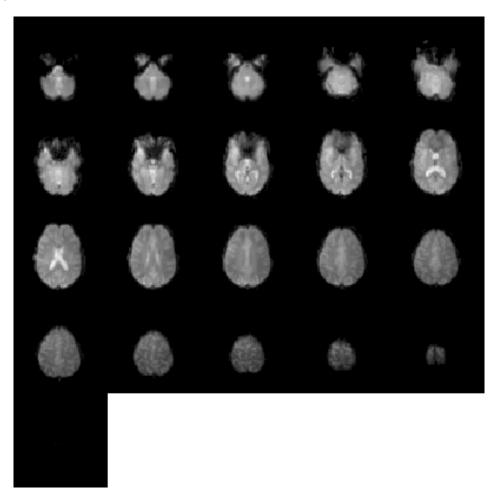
Axial slices of the functional MRI "volume" filtered_func_data from the first acquisition.
